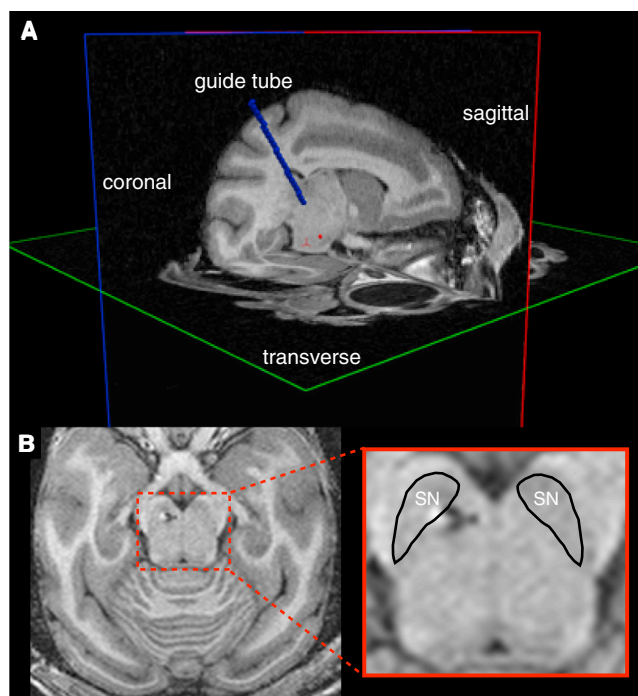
MRI-Guided Guide Tube and Electrode Implantation
